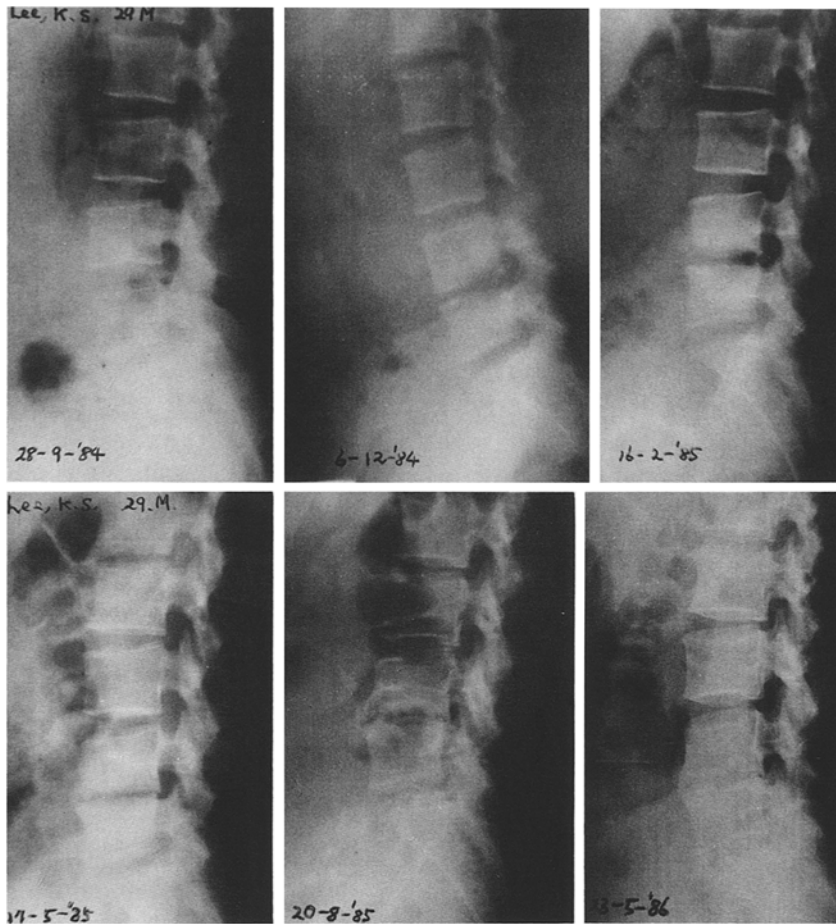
Lateral view of the L4-5 tuberculous spine of a 29-year-old patient taken on September 28, 1984, shows no abnormalities in the spine. Further X-rays taken on December 6, 1984 disclosed L4-5 disc narrowing and destruction of the lower plate of L4. Tuberculosis was diagnosed and chemotherapy started. The last follow-up X-ray taken in May 1986 disclosed solid fusion of L4-5 without residual kyphosis
